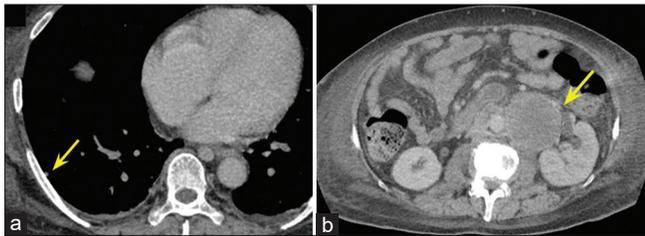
Computed tomography scan indicated disease progression. (a) Tiny lung nodules (yellow arrow) developed in the lung at 8 months. (b) Para-aortic lymphadenopathy (yellow arrow) developed at 11 months
